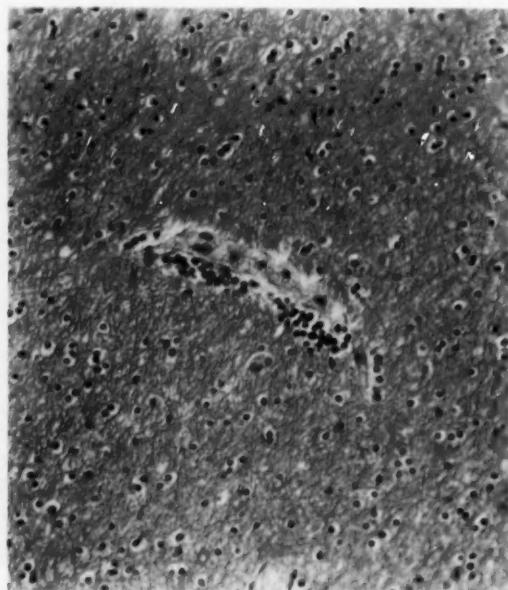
(Case 7).—Accumulation of glial cells along one side of a vessel in the path of an ultrasonic beam. Magnification, $\times 220$.
